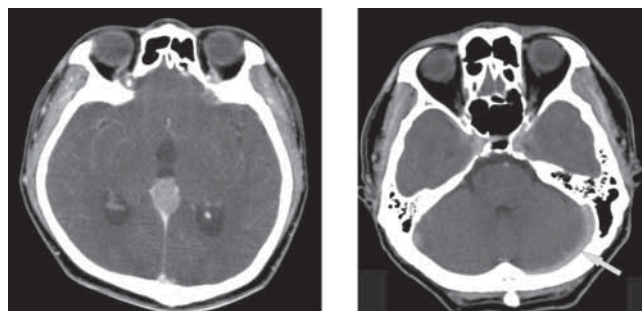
Left: CT with contrast enhance axial view showed homogenous strong enhancement lesion in pineal lesion. Right: Lower cut level of brain CT with contrast. There was no concomitant lesion found in cerebellum. The left transverse sinus is labeled (grey arrow).
